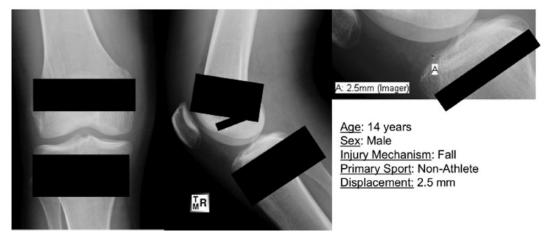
A sample vignette includes anteroposterior and lateral knee radiographs of a type II tibial spine fracture with patient and injury characteristics, as well as fracture fragment displacement value shown on zoomed lateral view.
